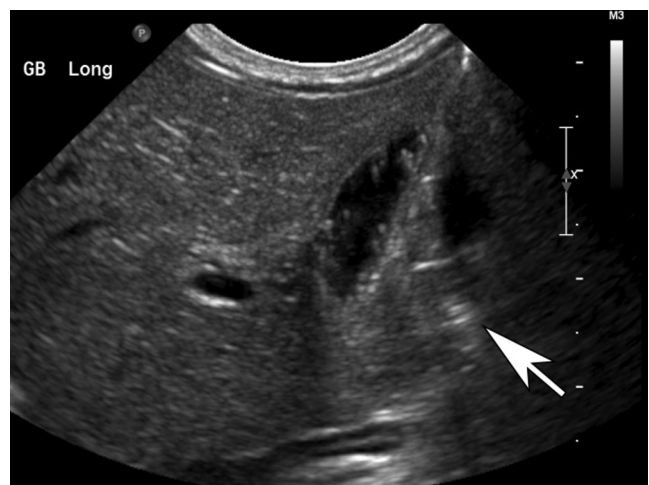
Ultrasound image shows gallbladder with comet-tail reverberation artifact (arrow), pathognomonic for adenomyomatosis of the gallbladder.
